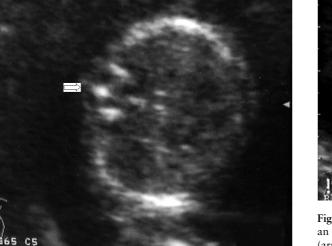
Case 3. Coronal and axial ultrasound images of vertebrae at 13 weeks' gestation showing diagnostic signs of diastematomyelia: (a) widening of the spinal canal in coronal section (arrow) and (b) additional echogenic focus in the posterior part of the vertebral column in axial section (arrow).
